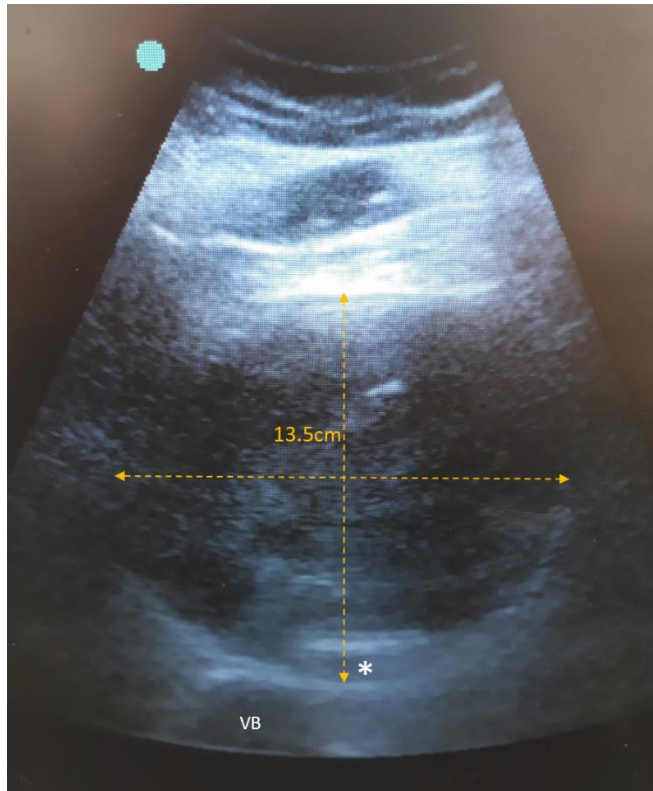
Ultrasound scan showing an epigastric transvers view of abdominal aorta (*) and a large aortic aneurysm (yellow arrows) measuring 13.5cm in diameter. VB= vertebral body.
